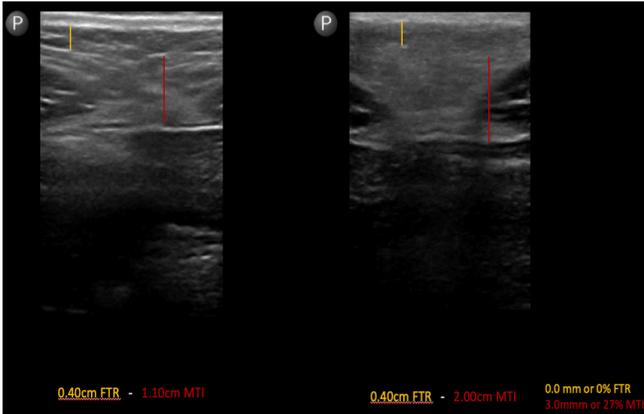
This was a 36-year-old female of Asian descent who received four treatments on her abdomen and flanks. The left ultrasound shows the baseline and the right ultrasound shows results at 12 weeks follow-up on her abdomen. She had a 27% Muscle Thickness Increment.
